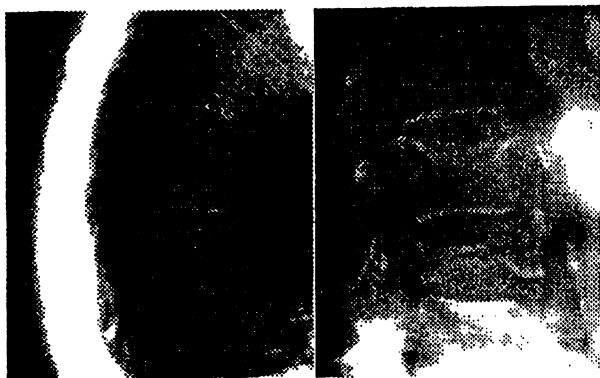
Codfishing and wedging on lateral spinal xrays.
